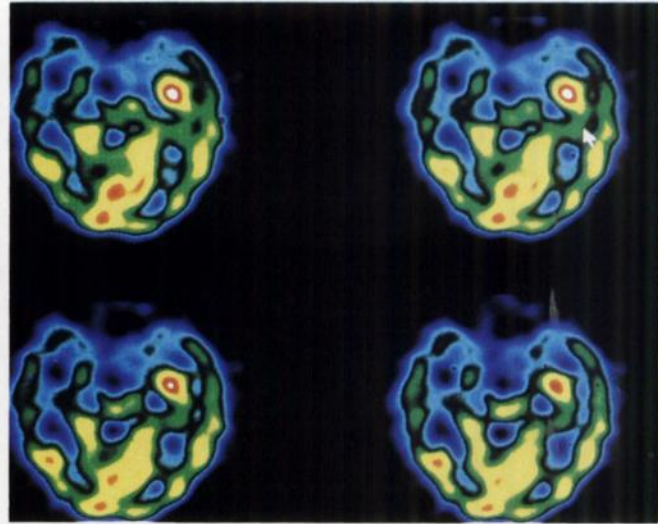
Technetium-99m-HMPAO-SPECT (four transaxial slices, parallel to the long-axis of the temporal lobes, 1.67 mm thickness). Markedly increased uptake is visible in the mesial part of the left temporal lobe (arrow). Uptake in the left temporal pole is slightly decreased.
